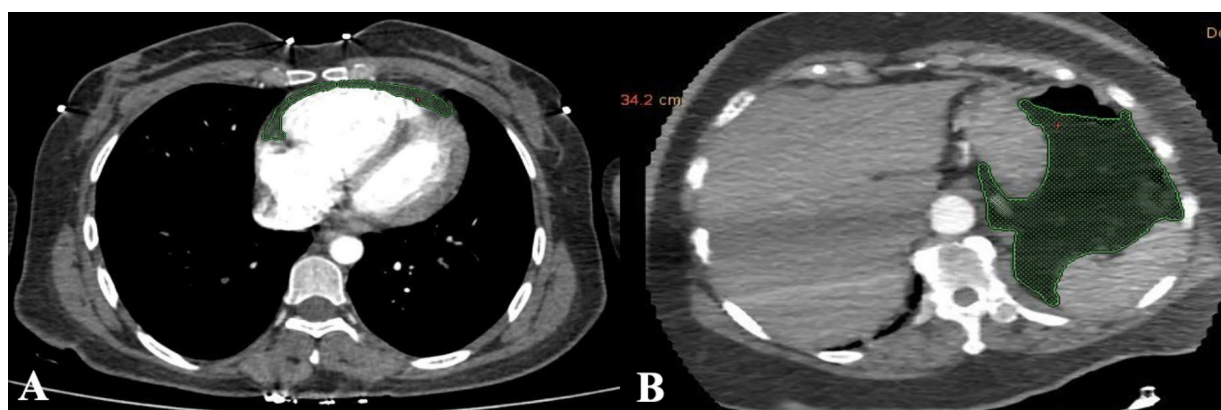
Epicardial and visceral fat thickness measurements. A, Epicardial fat thickness measurements obtained from the computed tomography images of a sample case. B, Visceral fat thickness measured using the axial section through the middle of the first lumbar vertebra (L1). The green area shows the visceral fat thickness area of a sample case).
